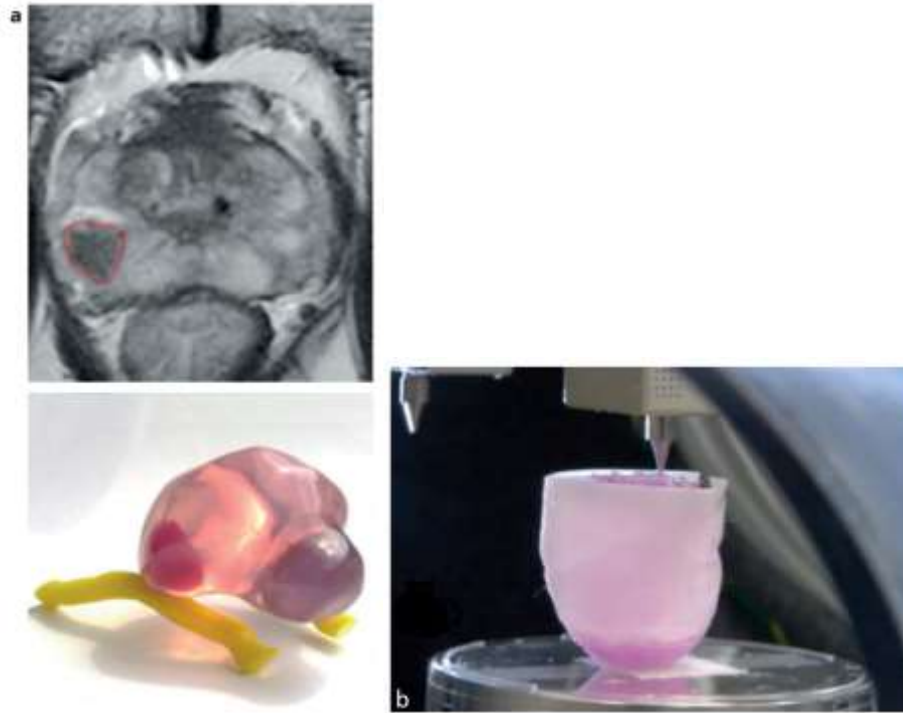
Applications of 3D printing in urology. A 3D model of a prostate tumor from an MRI is used for educating and training students for procedures (a). 3D printing can also be used for bioengineering of urological components, such as a kidney scaffold (b). Reprinted with permission from [10]. © 2018, Springer Nature.
